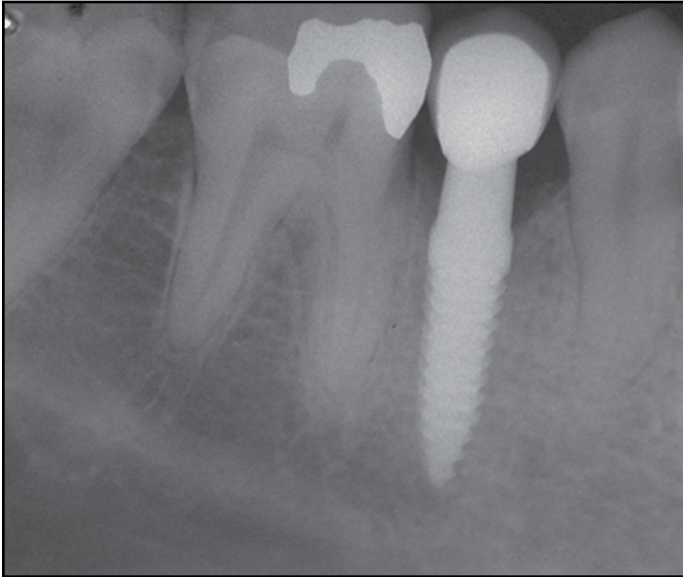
12 months postoperative periapical radiograph.
